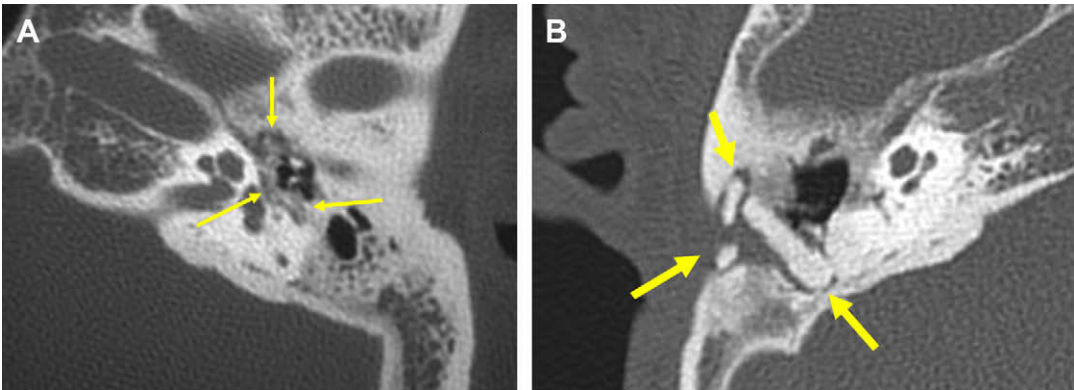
(A) Axial CT demonstrates mixed soft tissue and amorphous calcific change in the middle ear surrounding the ossicles and filling the tympanic sinus (arrows). Tympanosclerosis with ossicular fixation proved by subsequent surgery. (B) Tympanosclerosis should not be confused with attempts to obliterate a mastoid cavity with bone (arrows) or hydroxyapatite.
